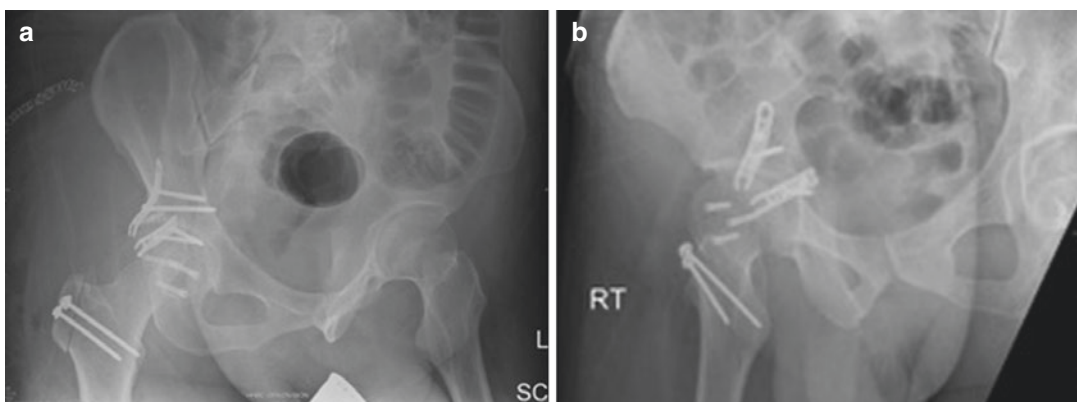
Postoperative obturator (a) and iliac-oblique (b) radiographs of the right Pipkin IV fracture. The femoral head fracture was stabilized using three variable-pitch screws that were countersunk to avoid prominent hardware at the articular surface (Postoperative radiograph. Hamilton General Hospital, Hamilton, Ontario. Taken with patient permission, January 2017)
